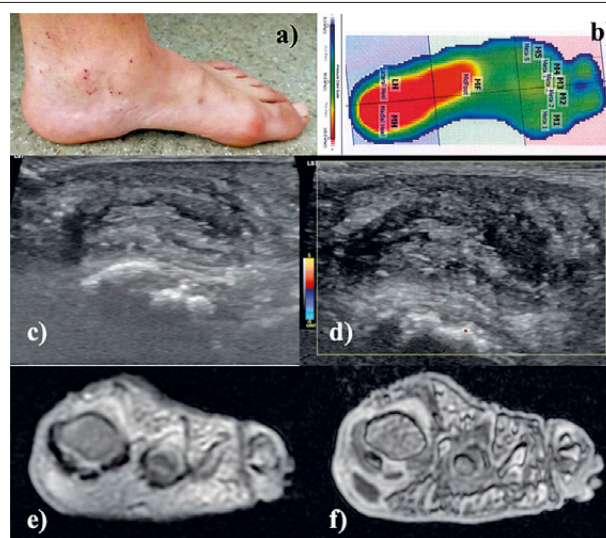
Female patient with SMB in the first submetatarsal region with the following findings: a) clinical examination: flat foot; b) baropodometry: flat foot and increased contact surface of the first submetatarsal region (17.9 cm²); c) US: ill-defined heterogeneous area within the fat pad under the first metatarsal head, d) without PD signal; MRI: e) ill-defined heterogeneous mass within the first submetatarsal fat pad with high signal intensity on coronal STIR sequences and f) peripheral enhancement on post-contrast coronal 3D T1 FSPGR., with central non-enhancing area.
